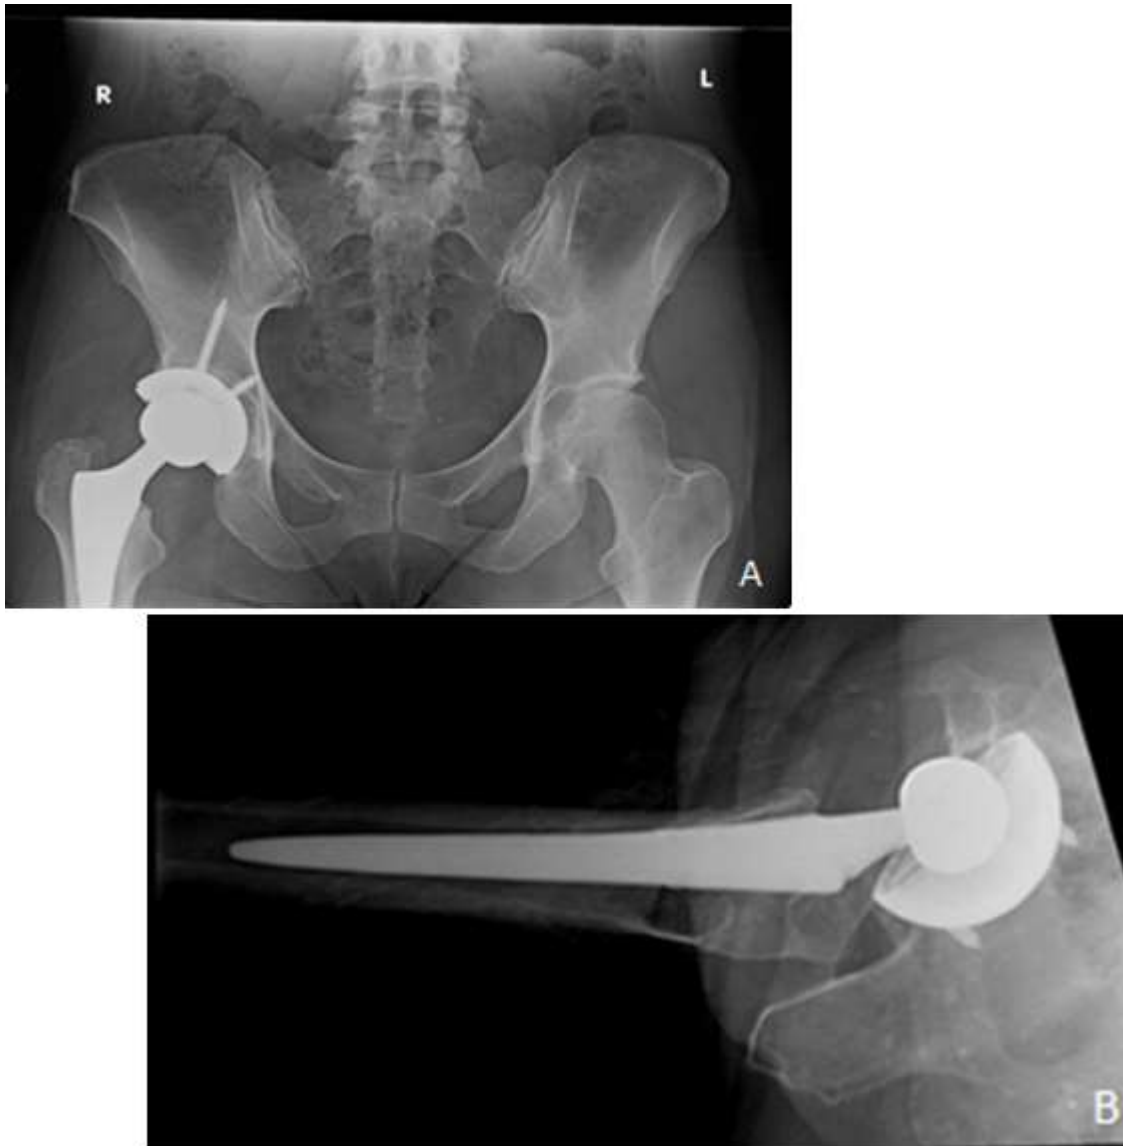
Radiographic views for evaluation of a total hip arthroplasty
